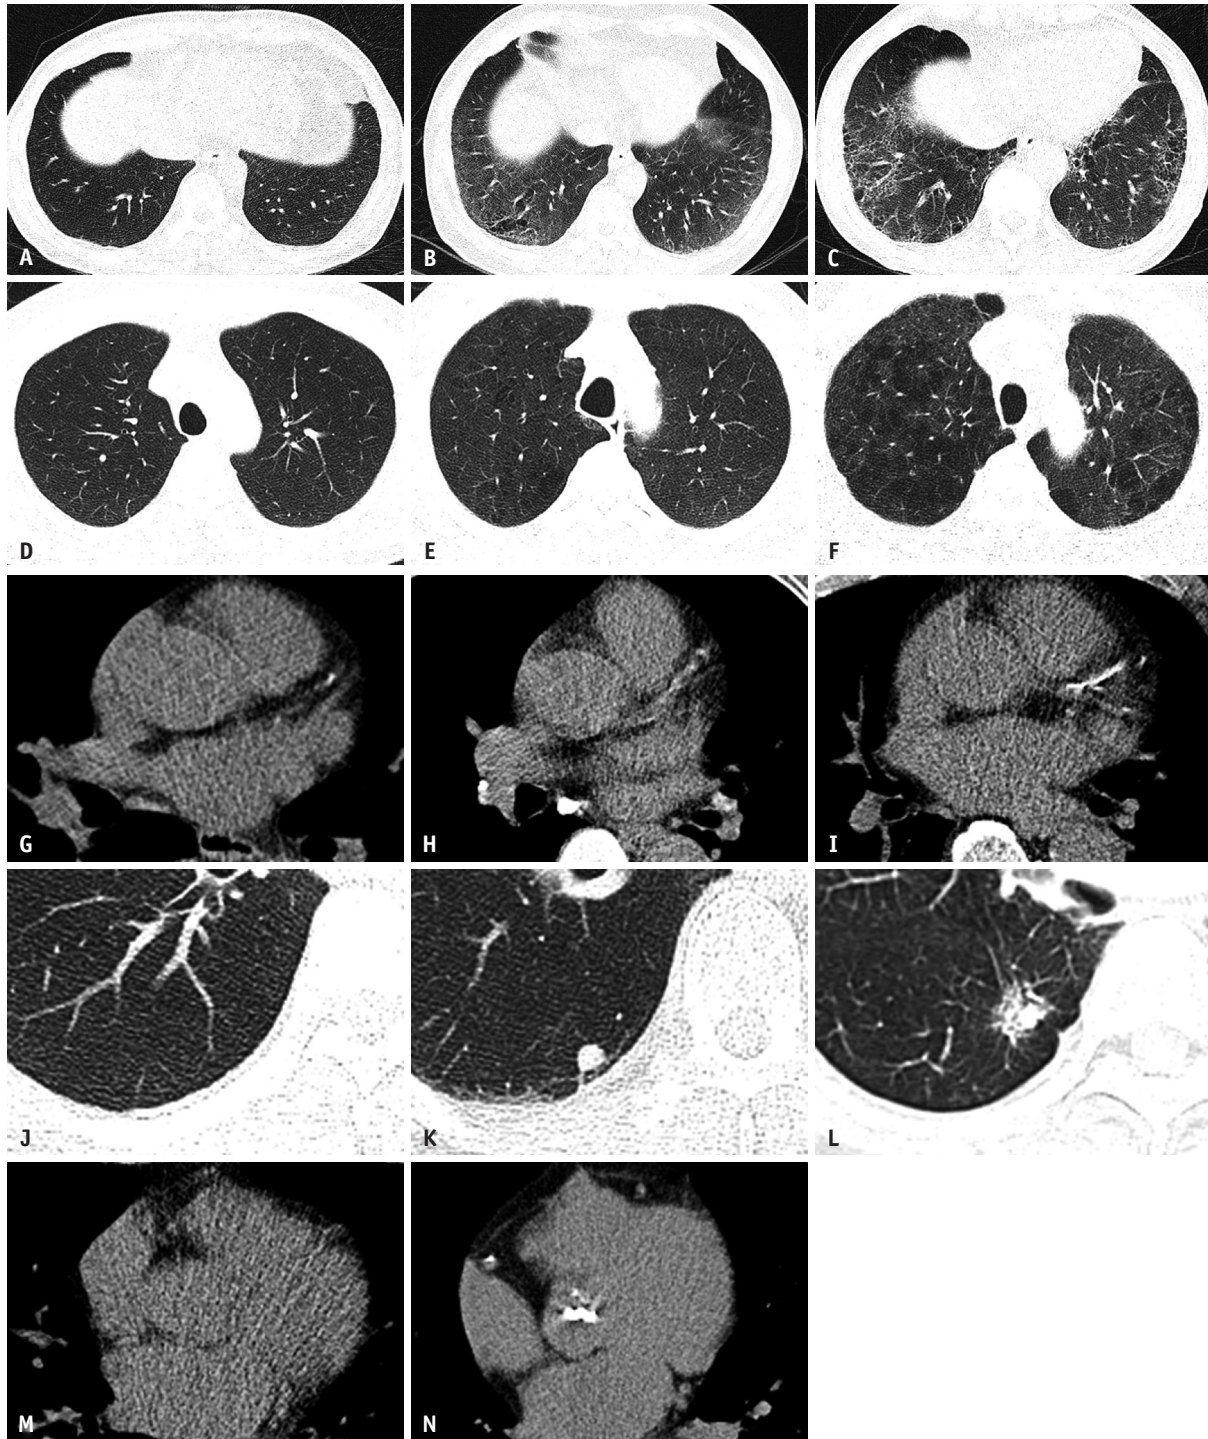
Representative cases of incidental abnormalities and pulmonary nodules observed on CT.
